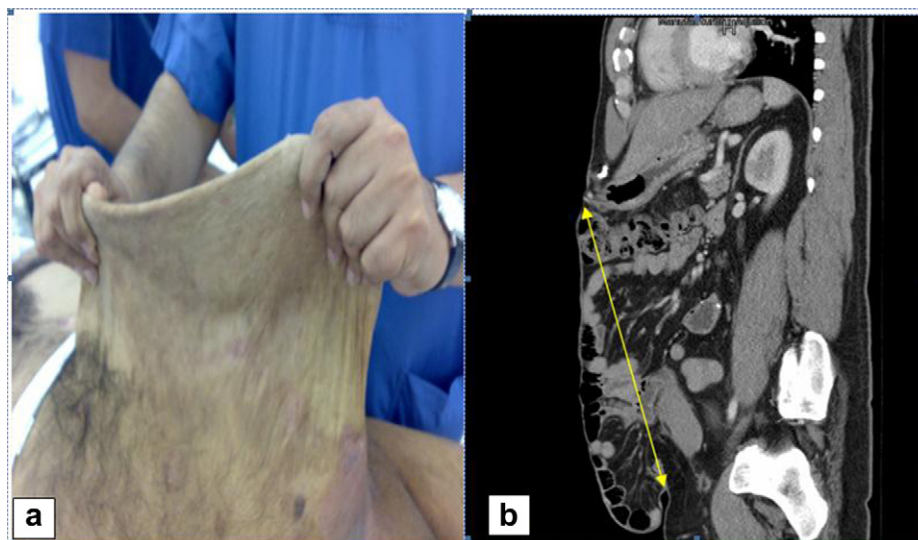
Shows a giant incisional hernia with just a skin fold overlying it (a). The arrow in the adjacent CT scan picture (b) signifies defect size and the contents protruding through it.
